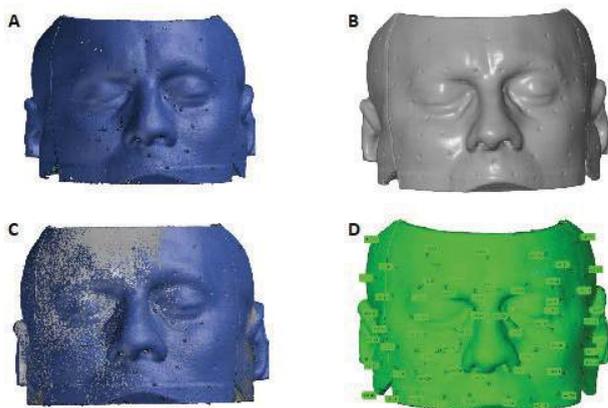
The stages of the deviation analysis between the highly accurate laser scan and CT data. A) The STL file of the laser scan was defined as the reference index. B) The CT scan data was converted from DICOM data to STL format. C) The CT scan and reference index were crudely aligned (pre-alignment). D) The CT scan and reference index were accurately superimposed and deviations were measured at 56 consistently visible points.
